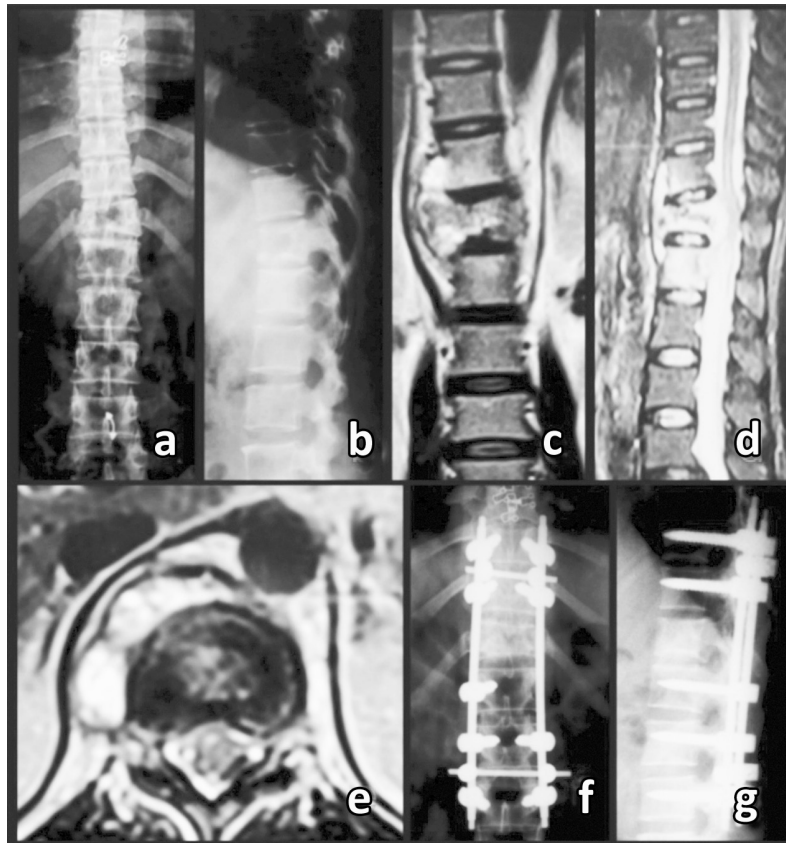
a, b, c, d, e - Plain x-ray and MRI of a 38 years old lady showing involvement of D 12 and L 1 vertebrae along with pre- and para-vertebral abscess. X-rays showing fairly maintained vertebral height with slight asymmetrical collapse whereas MRI showed two vertebrae involvement. f, g - Immediate and one year post - posterior instrumentation showing healed lesion and good spinal alignment.
